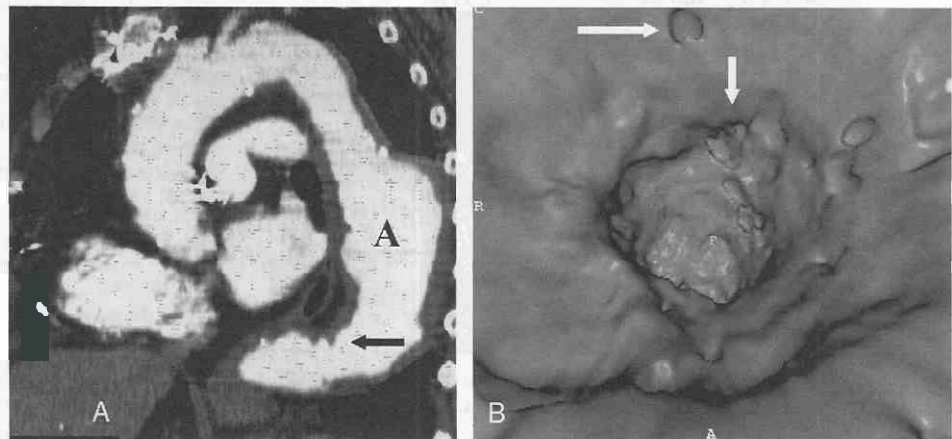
A, Sagittal oblique multiplanar reconstruction from CT scanning in an older woman who presented with chest pain. There is aneurysmal dilatation of the descending thoracic aorta (A) with marked irregularity or ulceration (arrow). B, Virtual endoscopic image of the descending aorta shows extensive ulceration (arrows).
